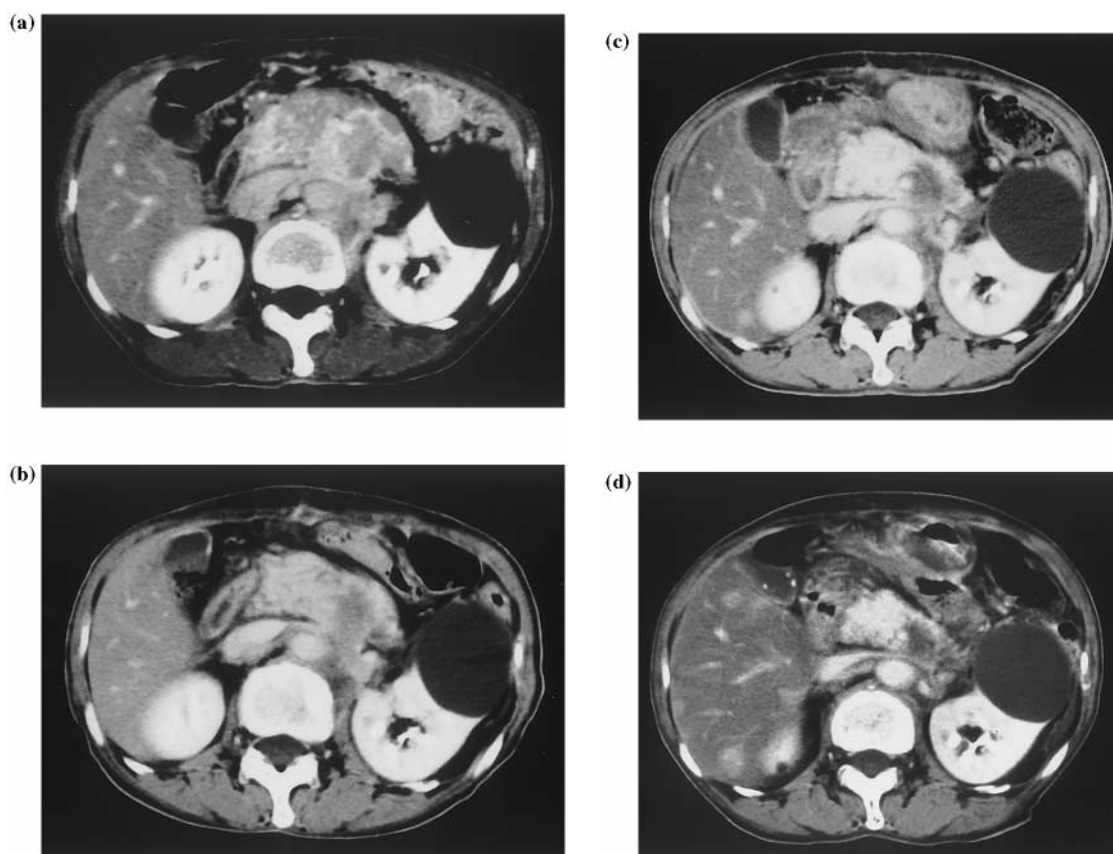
This 71-year-old female patient with adenocarcinoma in the pancreatic body was treated with preoperative EBRT (41.4 Gy) and IORT (20 MeV, 30 Gy). Typical tumor regression was noted in these serial CT images. (a) Pretreatment CT scan. The huge tumor in pancreatic body and tail was noted. (b) One month after IORT: tumor regression was not evident. (c) Four months after IORT: significant tumor regression was noted. (d) Seven months after IORT, the tumor volume was the same as that at 4 months after IORT. Liver metastasis was noted at this time.
